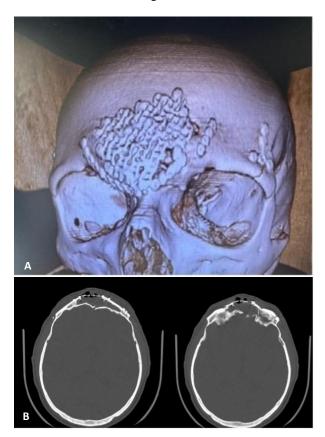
(A and B): Postoperative CT scan of the head on fifth day after operative treatment.
